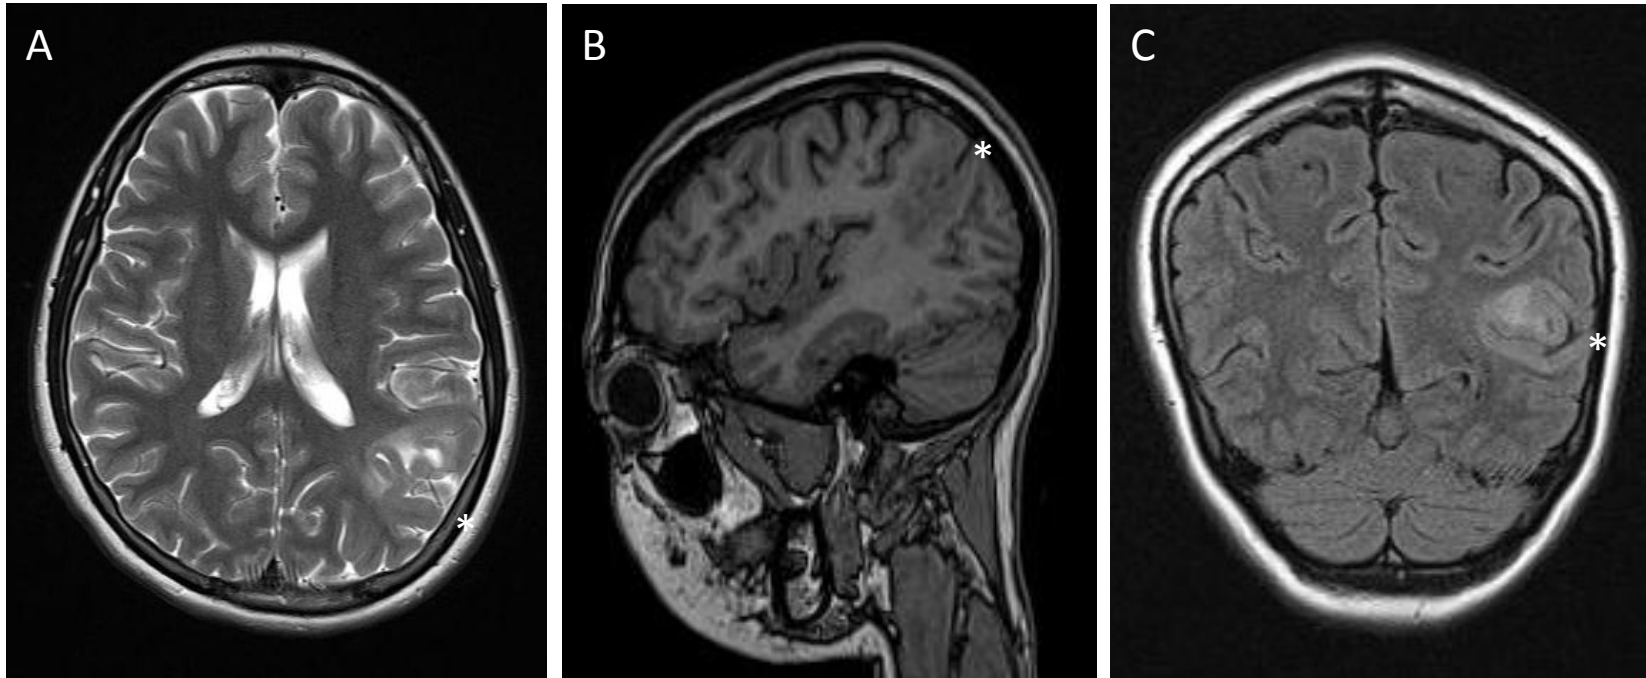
White matter type focal cortical dysplasia in a 3-year-old-girl. (A) Axial T2-weighted MRI shows severe hyperintense signal changes in the left parieto-occipital region. The margin between the cortex and white matter is blurred on the T1-weighted sagittal image (B), but is discernible on the coronal fluid-attenuated inversion recovery (FLAIR) image (C).
